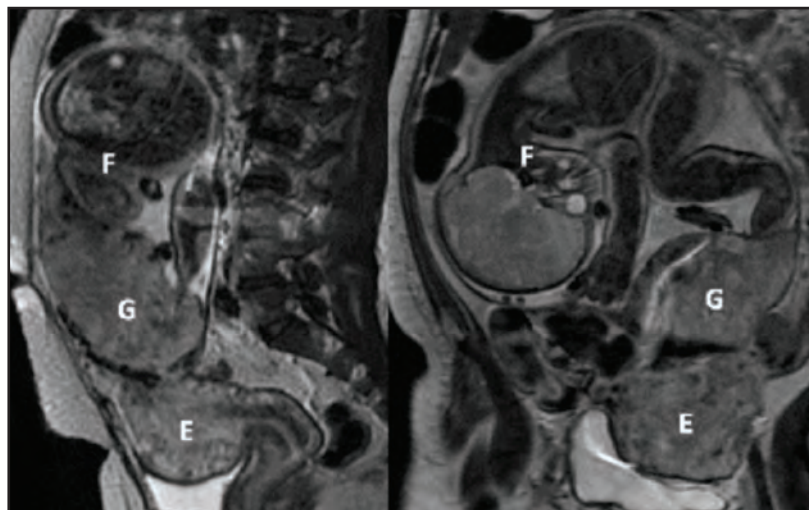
MRI image. Left sagittal view, right coronal view; (E)uterus; (F) fetus; (G) placenta.
